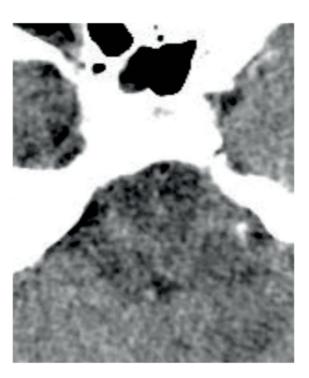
CT Skull with contrast. Posterior peripheral flow.
